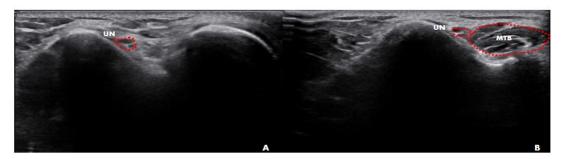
Sonographic view of ulnar nerve and medial head of triceps brachii
